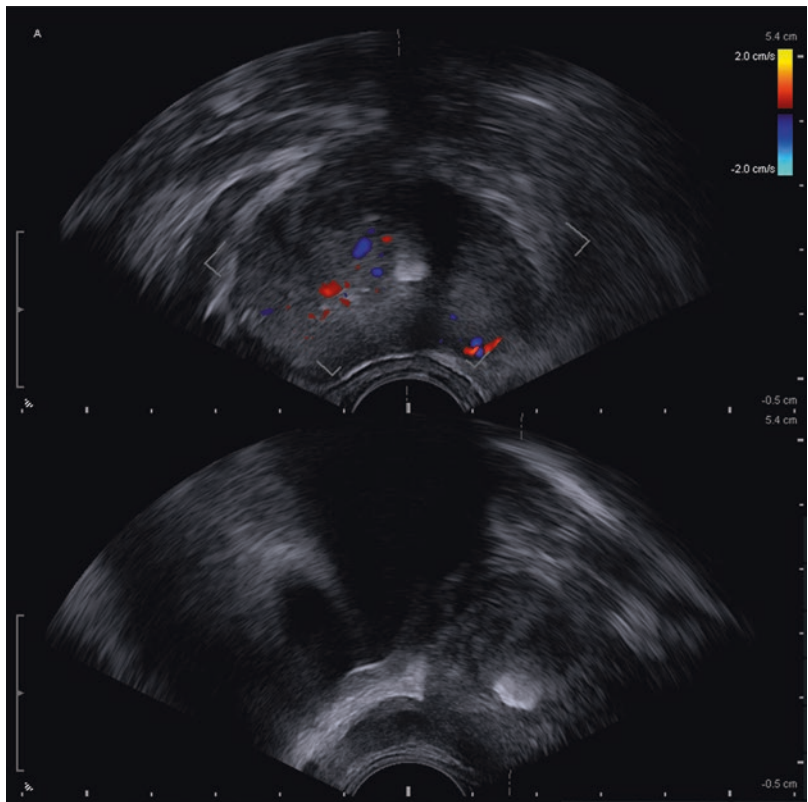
Split screen representative color flow views of prostate with transverse (top image with color Doppler) and longitudinal (lower image) views
